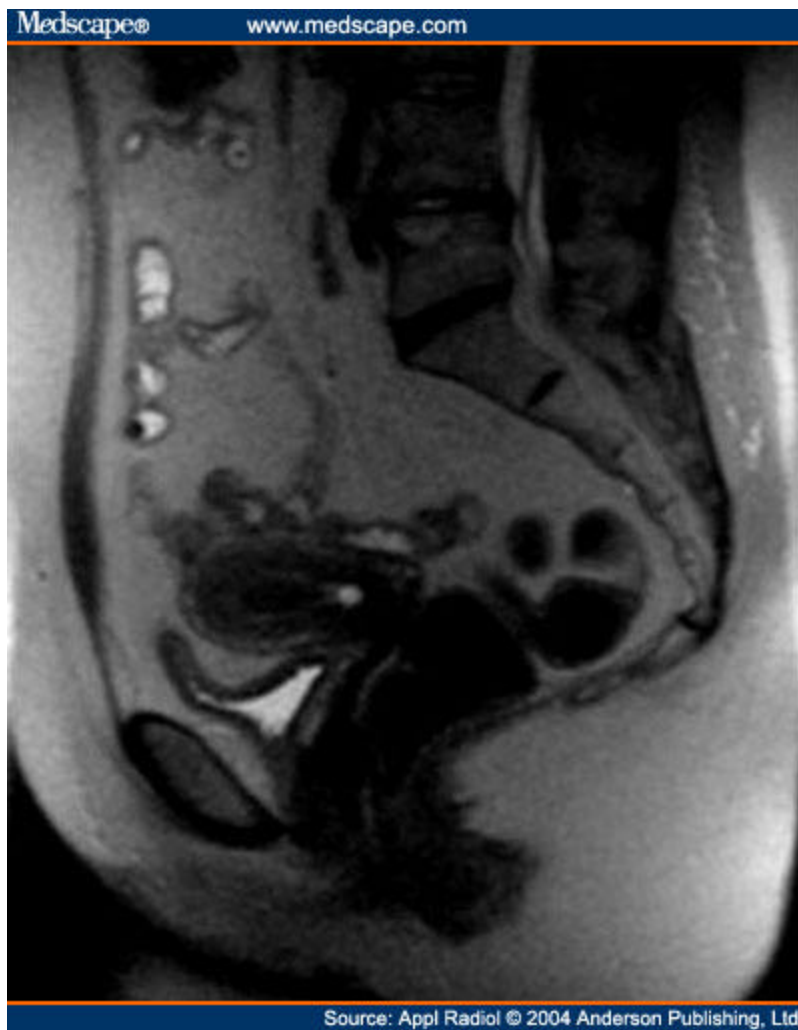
This midline sagittal T2-weighted MRI shows a small low-signal lesion within the confines of the endometrial cavity. This is likely a pedunculated fibroid or polyp, both of which can result in menorrhagia. This lesion is best treated by hysteroscopic removal.
